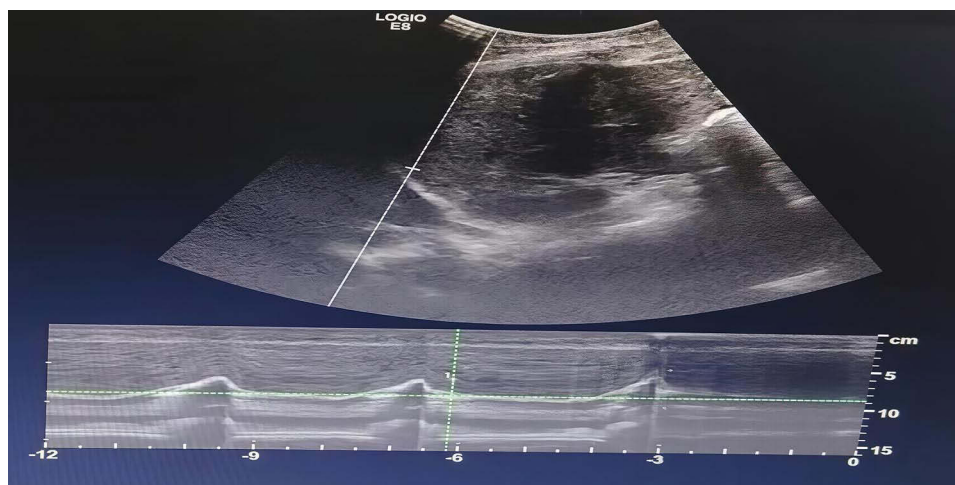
Ultrasonographic measurement of DE. The liver is used as an acoustic window. The M-mode sampling line is directed toward the diaphragmatic dome. The white undulating wave line indicates the amplitude of diaphragmatic movement.
